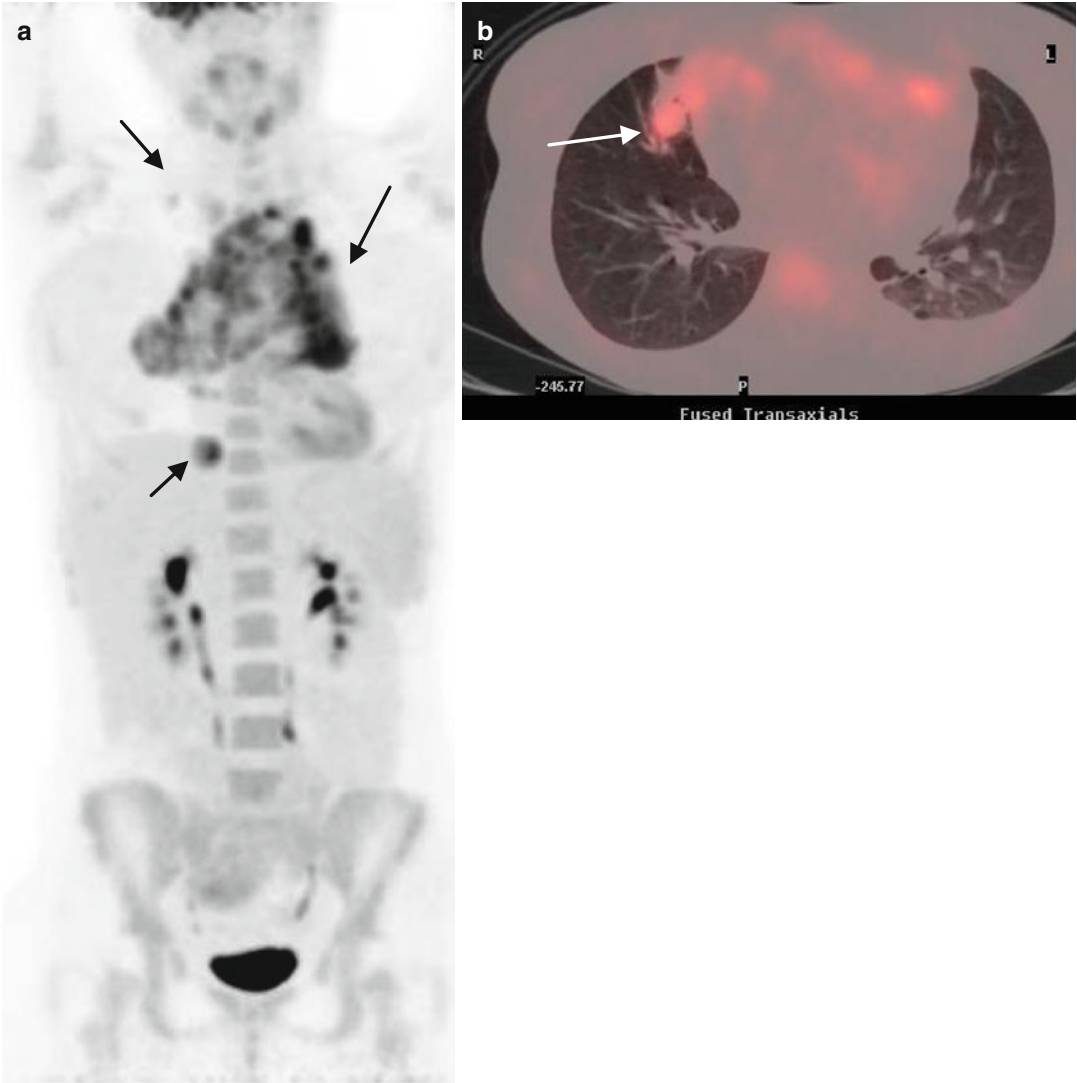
(a, b) PET/CT staging revealed increased 18-FDG uptake (SUVmax 9) at the mediastinum and right epiphrenic area (a – *black arrows*) but also demonstrated
